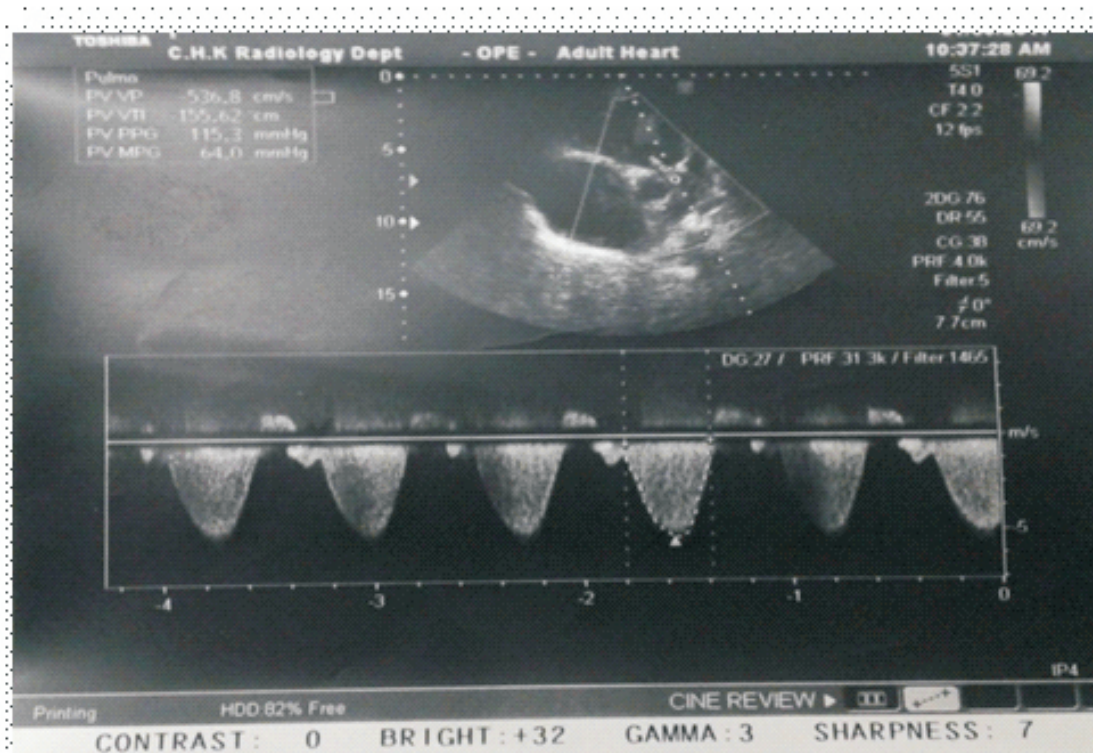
Color Doppler showing turbulent flow in the pulmonary artery.
